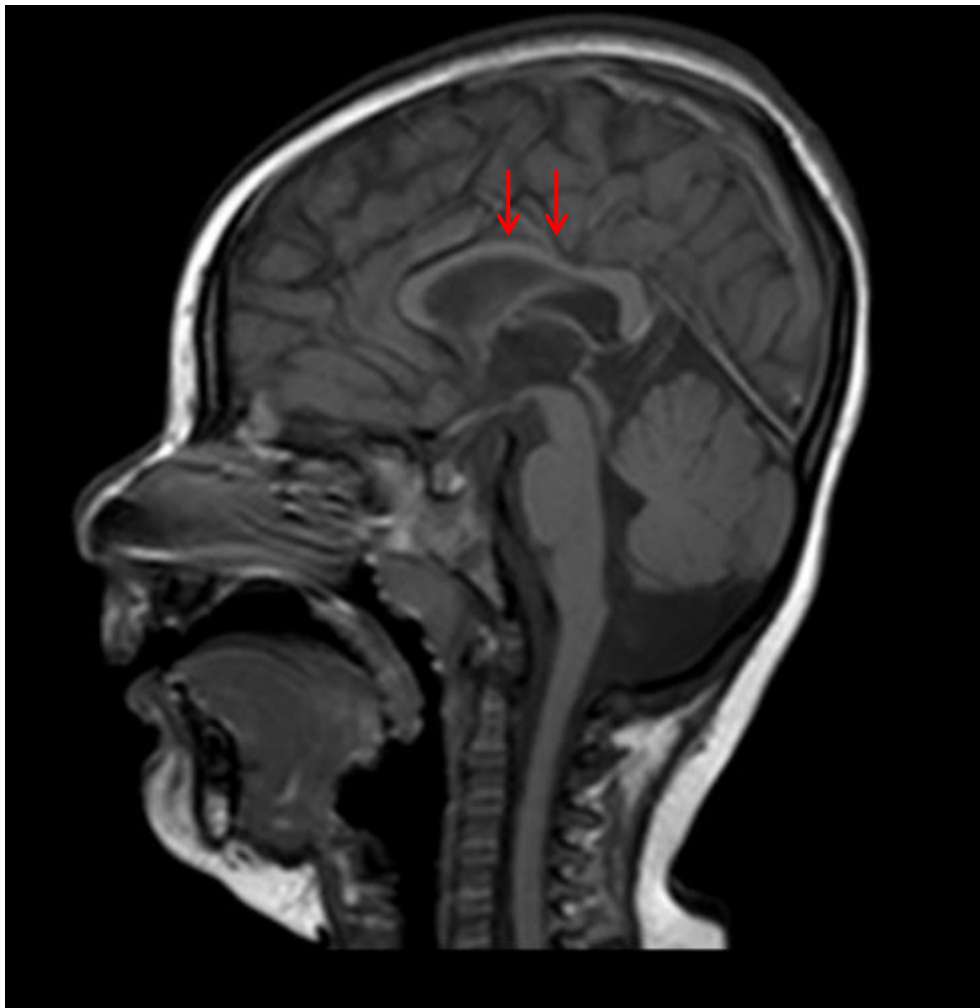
(B) MRI brain scan of III.6 at 2 years. The sagittal weighted image (B) shows a reduction in the bulk of the corpus callosum as indicated by the red arrow heads.
